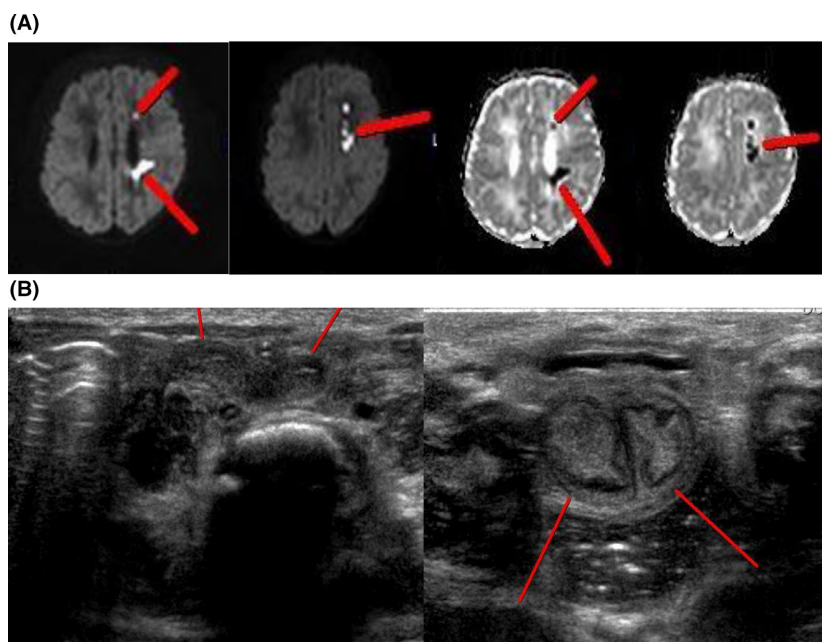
(A) Brain MRI c DWI shows patchy diffusion restrictive lesions in the left fronto-parietal white matter. (B) Uterine didelphys, showing the double uterus and double cervix.
